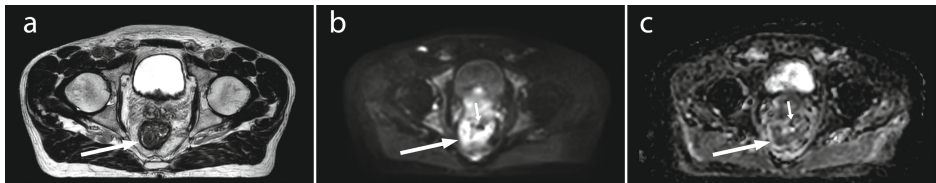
Representative example of a rectal cancer patient. (a) T_2 -weighted image, (b) DWI $b = 500 \text{ s/mm}^2$ image, and (c) ADC map (scaled between 0 and $4 \times 10^{-3} \text{ mm}^2/\text{s}$). The large white arrows indicate the location of the tumor. On the DWI and ADC images, the tumor shape is slightly deformed due to the presence of air (small arrows).
